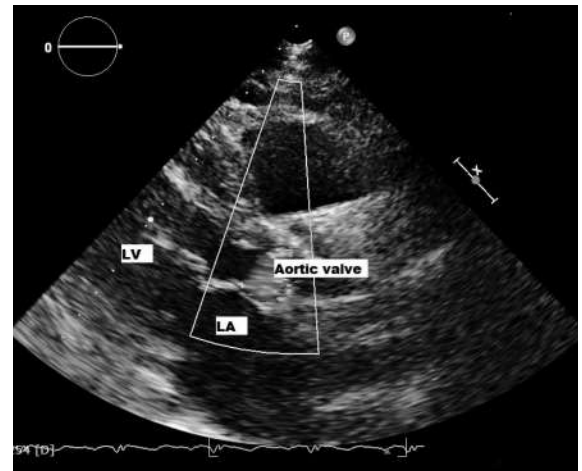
Echocardiography shows a slightly enlarged left ventricle with normal contraction.
